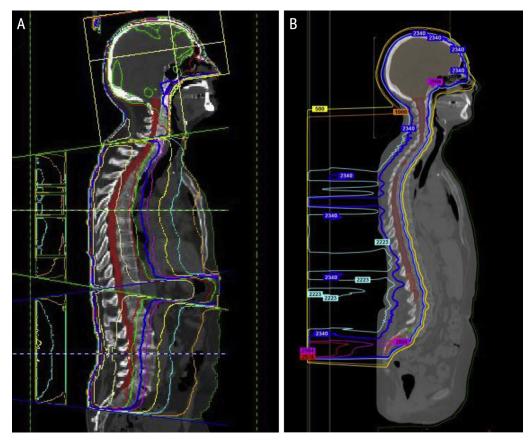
(A) Dose distribution for photon (x-ray) craniospinal irradiation. (B) Dose distribution for proton craniospinal irradiation.
